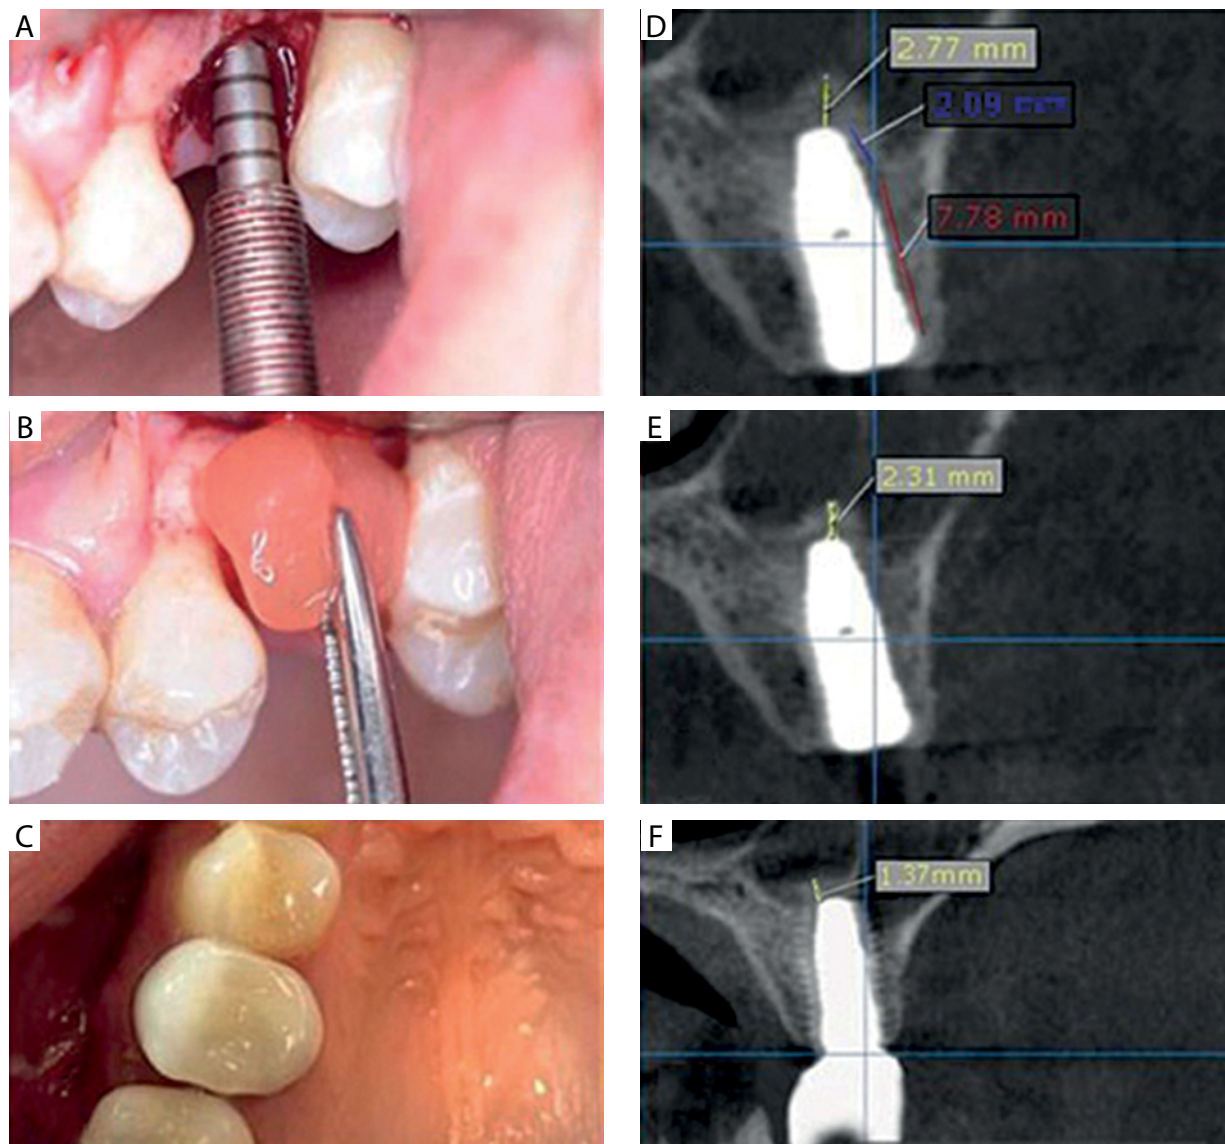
Osteotome application (A), AFG application (B), crown placement (C), post-operative CBCT (cross-section view) showing ■ graft apical height, ■ implant protrusion, and ■ residual bone height at T⁰ (D), GHA at T³ (E), and GHA at T⁹ (F)
